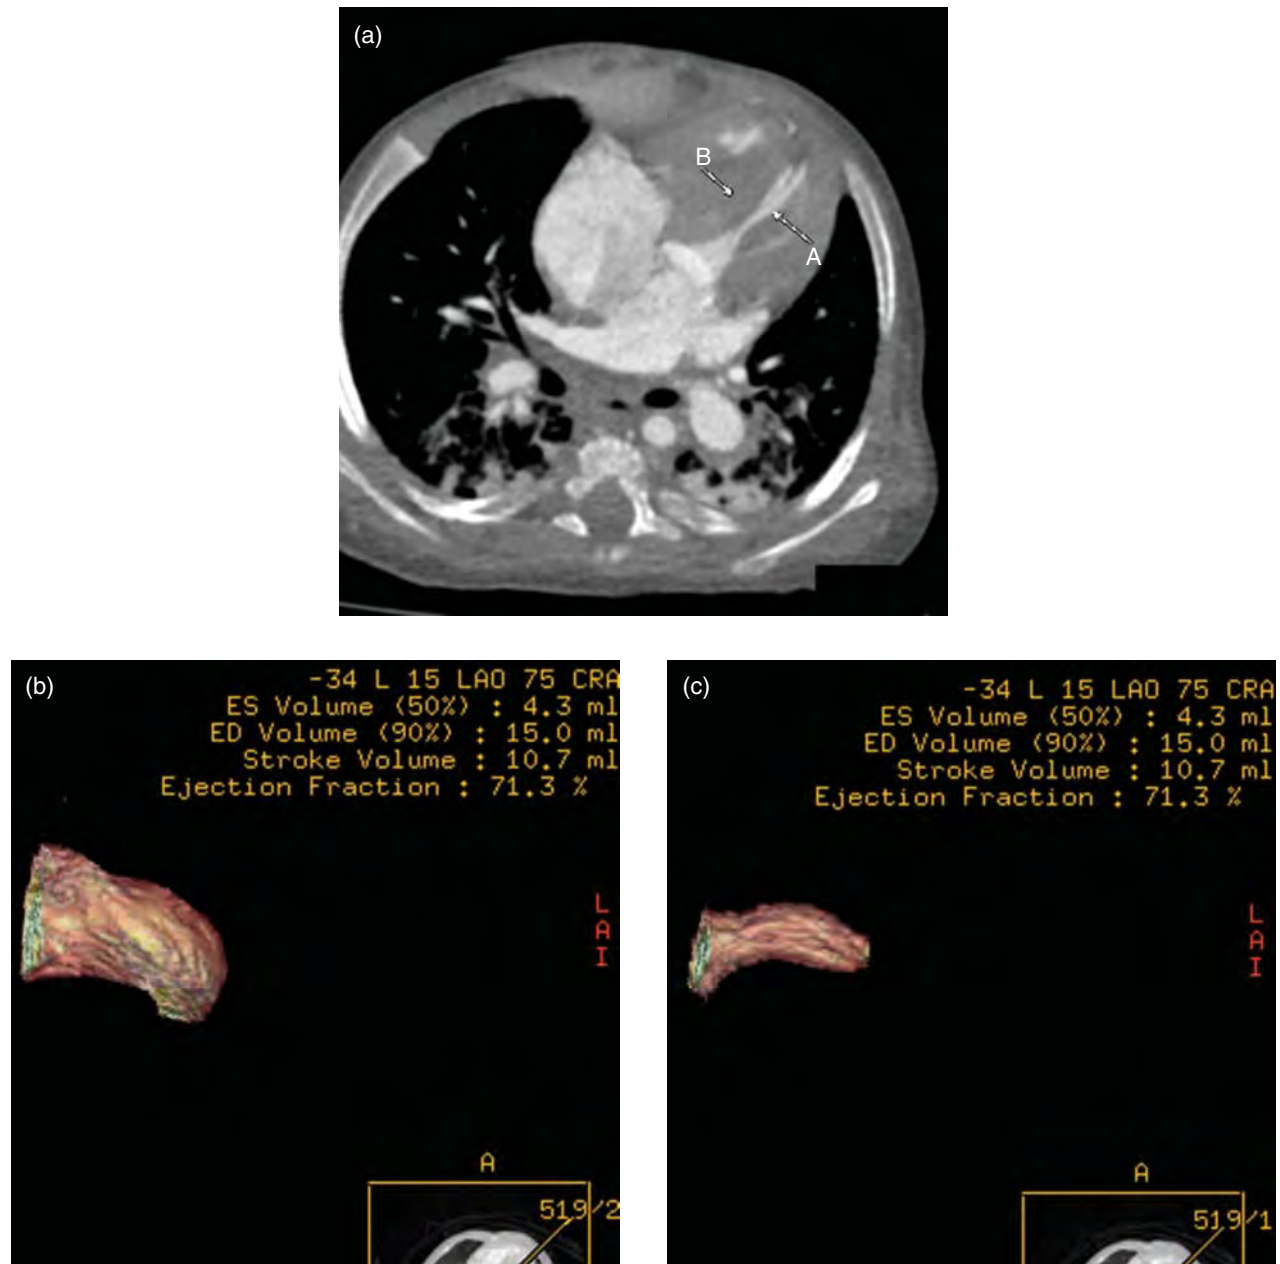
(a) An axial and (b,c) two volumetric images from a cardiac CT in an infant with an obstructive cardiomyopathy shows marked thickening of the muscular ventricular septum and left ventricle. The post-processed functional analysis shows a hyperdynamic ejection fraction measuring 71.3%. Notice the gross volume measurements: end systolic (ES) volume = 4.3 mL, end diastolic (ED) volume = 15 mL, and stroke volume = 10.7 mL. Indexed volumes may be obtained by dividing the gross volume by the body surface area.
